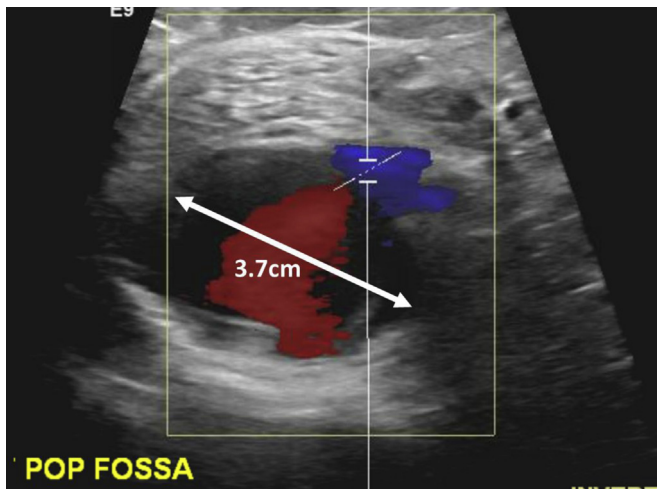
Duplex ultrasound examination was performed to evaluate for venous thrombosis. A pseudoaneurysm of 3.7 cm in diameter was noted in the popliteal fossa as an incidental finding.
